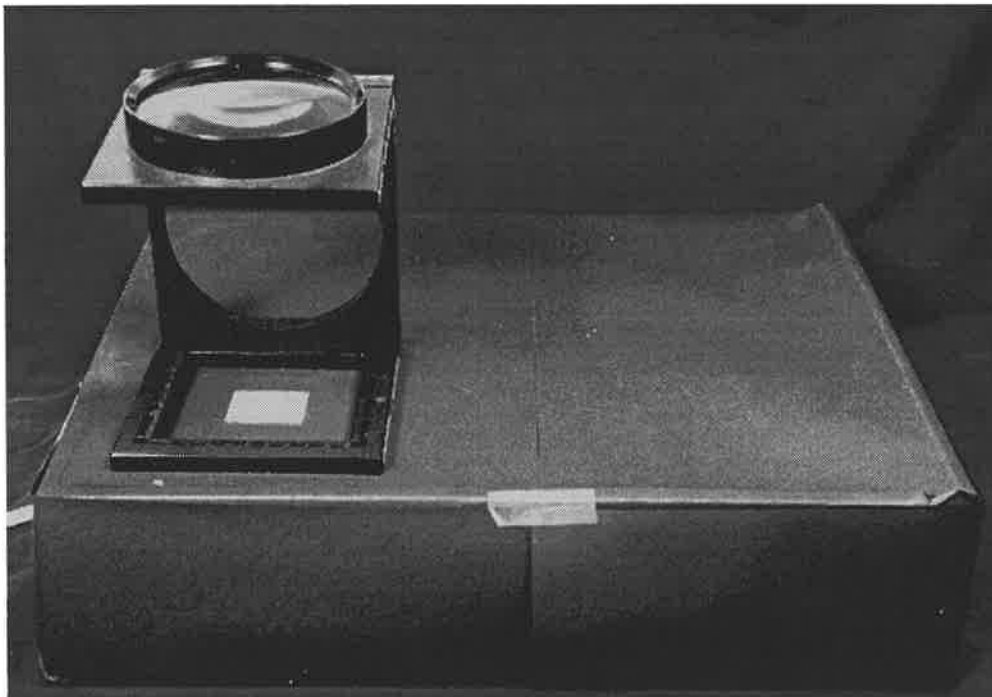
Radiograph viewing box
